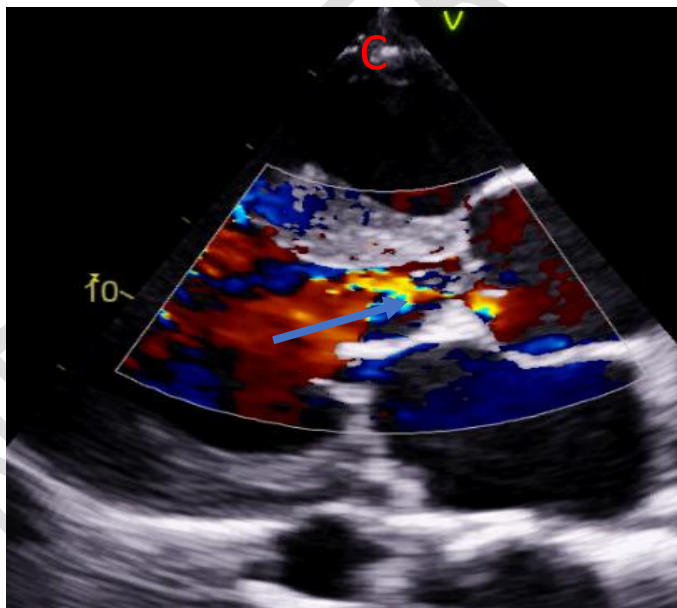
Transthoracic echocardiography (TTE): A- long-axis parasternal view: Hypertrophy of the LV, echogenic image visible in systolic time on the posterior cusps.
